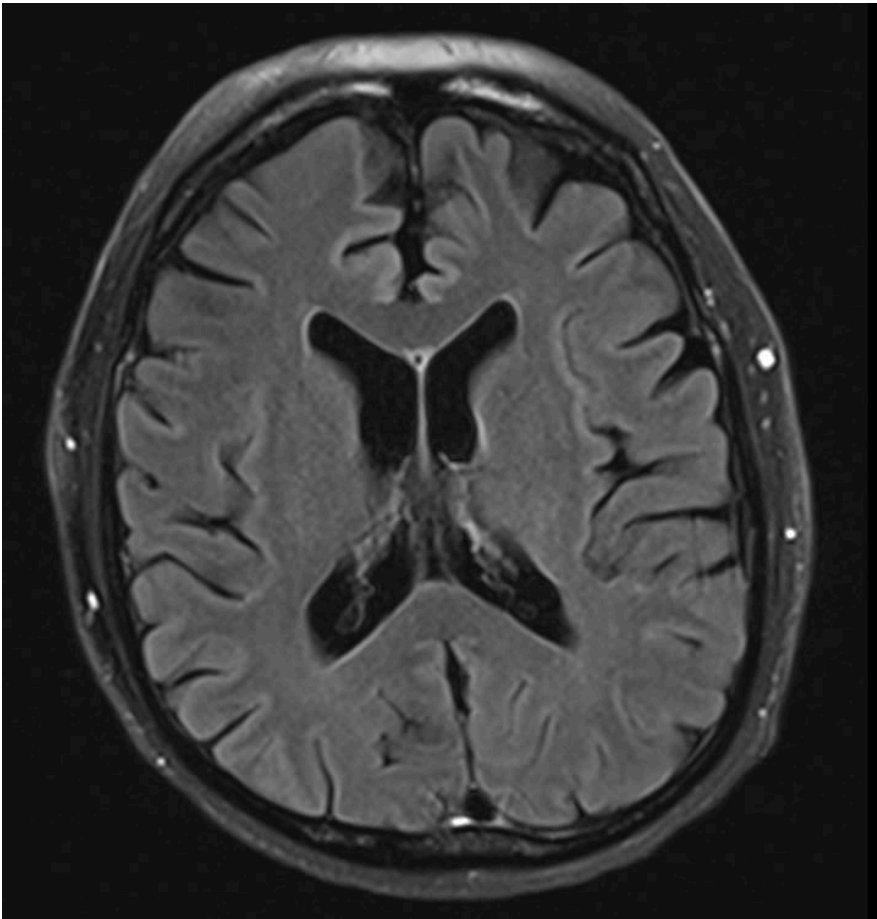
Symmetric Increased T2-FLAIR MRI signal along the splenium.*
